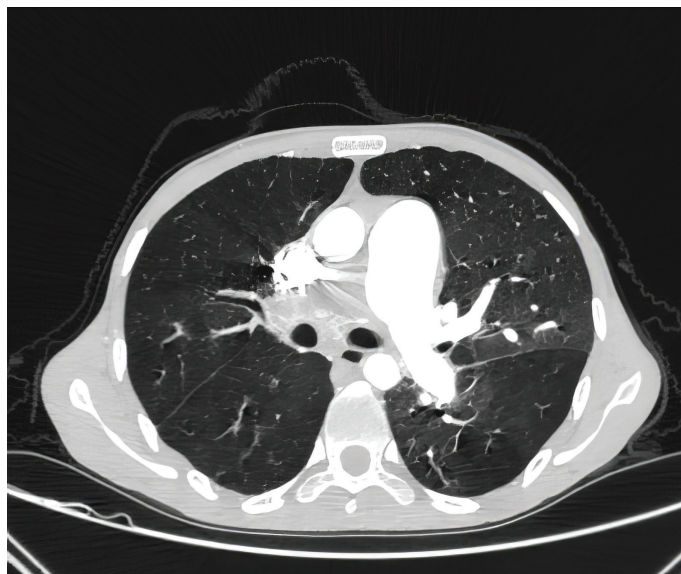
Pulmonary arterial thrombosis and aneurysm in the main arteries were observed in the transverse sections of computed tomography of the thorax.
